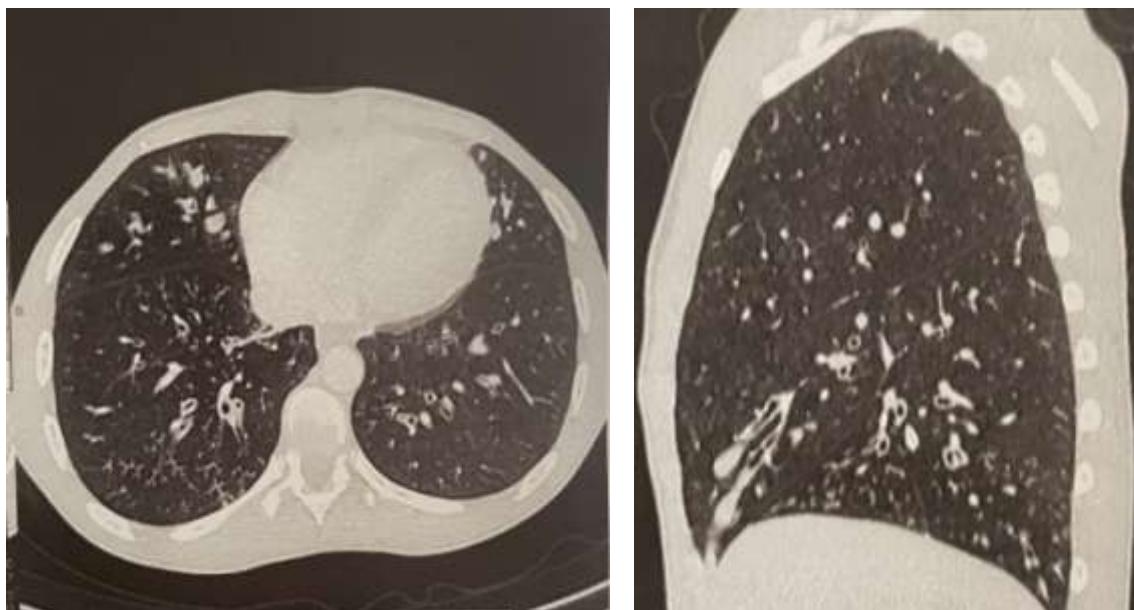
Thoric CT scan revealing bilateral bronchiectis
